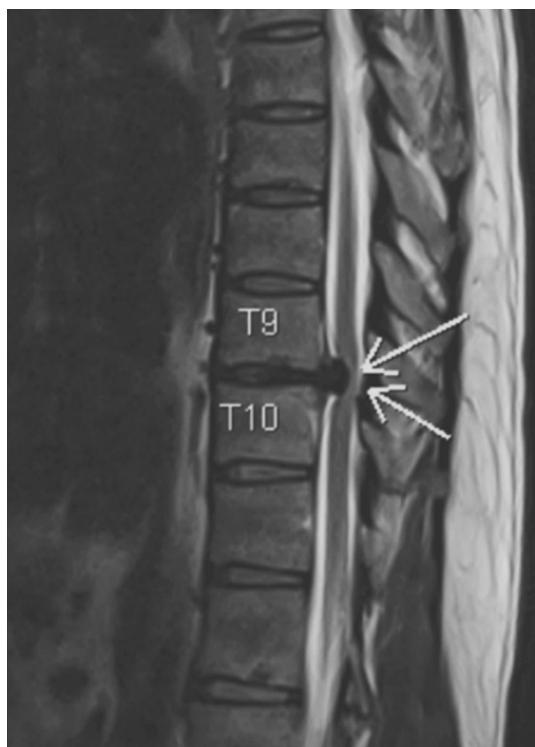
Preoperative sagittal T2-weighted MRI showing a huge T9/10 prolapsed intervertebral disc causing spinal cord compression and myelomalacic changes of the spinal cord
